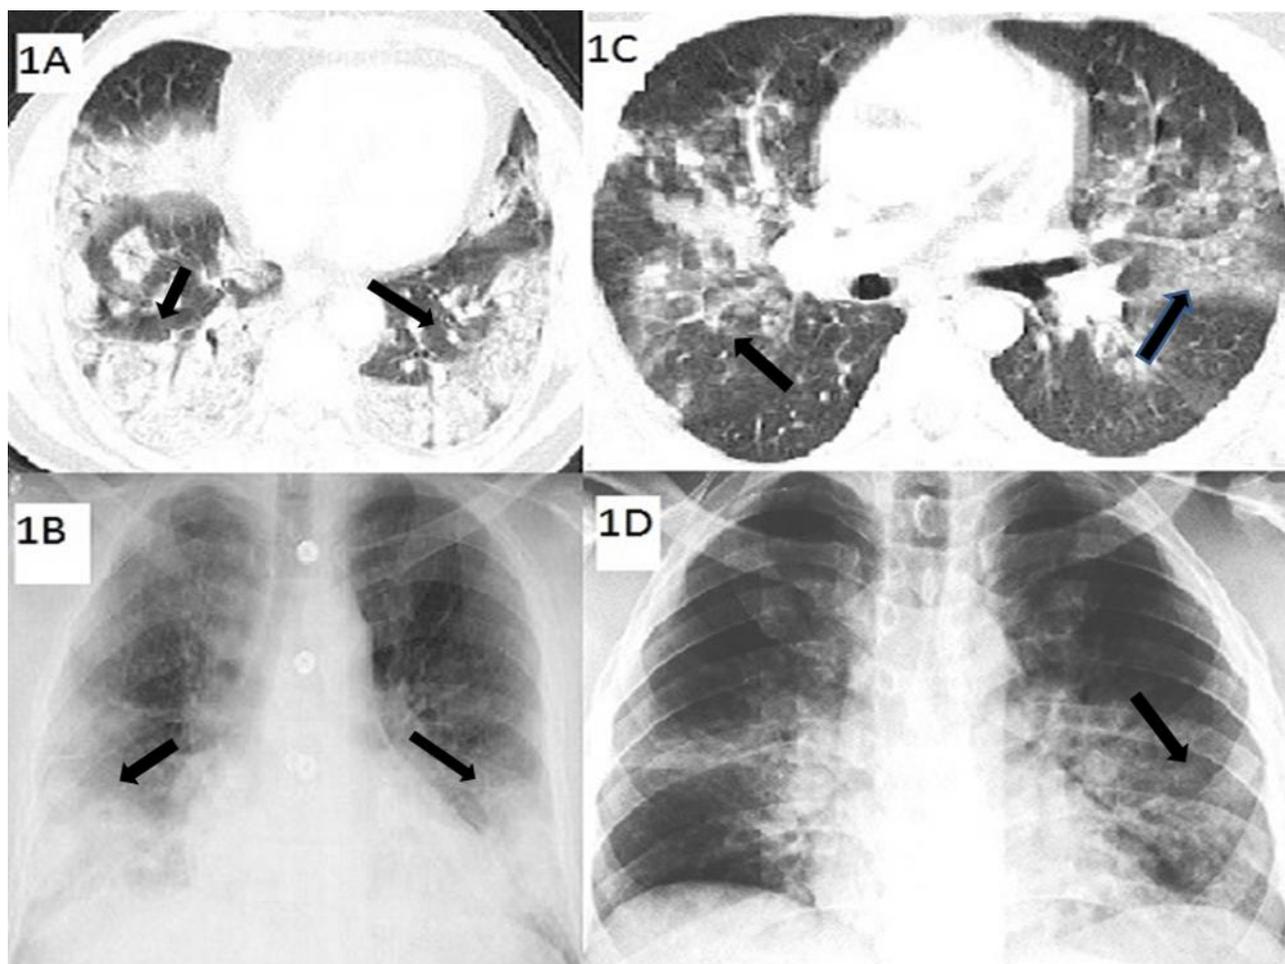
Figure shows computed tomography and chest x-ray images of one died (1A, 1B) and another one survived (1C, 1D) patients. The arrows show localization of infiltrates on radiography
